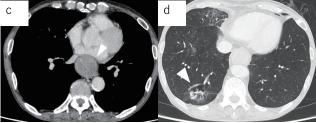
Endoscopic and CT findings before chemotherapy a, b) Upper gastrointestinal endoscopic findings: A fully circumferential type 2 tumor was found from middle to lower thoracic esophagus.
